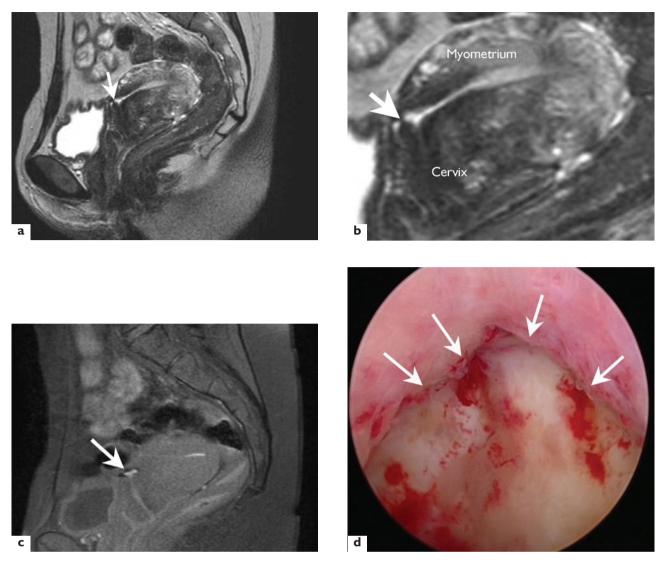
(a) and (b) Magnetic resonance imaging (MRI) showing the thickness of the anterior uterine wall (white arrow), highly suggestive of a wide and deep dehiscent cesarean scar. MRI evaluates the residual thickness between the dehiscent scar and the peritoneum at less than 1 mm. (c) Sagittal view of the lower uterine part in T1-weighted image with fatty tissue saturation. Hyperintensive signal (white arrow) is highly suggestive of old blood retention in the cesarean scar dehiscence. (d) Hysteroscopic view of the scar dehiscence (white arrows)
